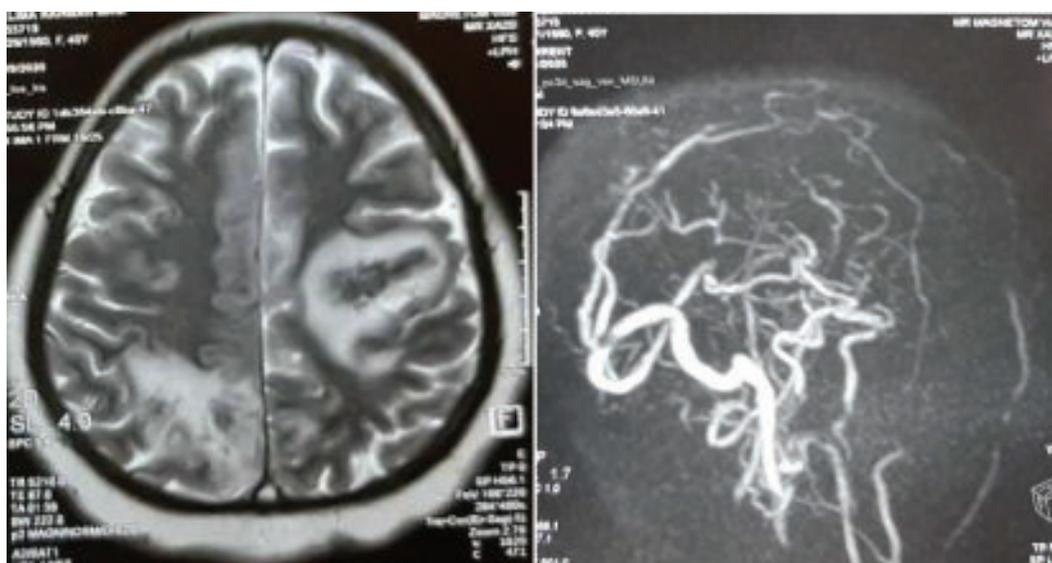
MRI and MRV showing venous infarction and cerebral venous sinus thrombosis
